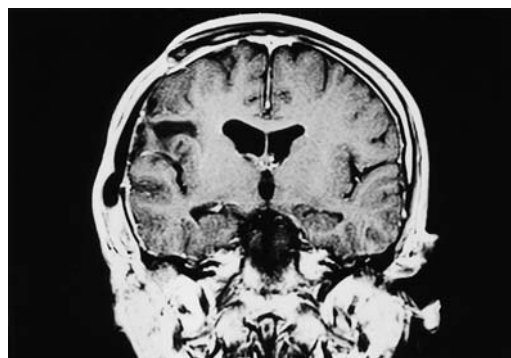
Postoperative contrast-enhanced coronal T₁-weighted MR image demonstrating total removal of the mass lesion with disappearance of the midline shift.
